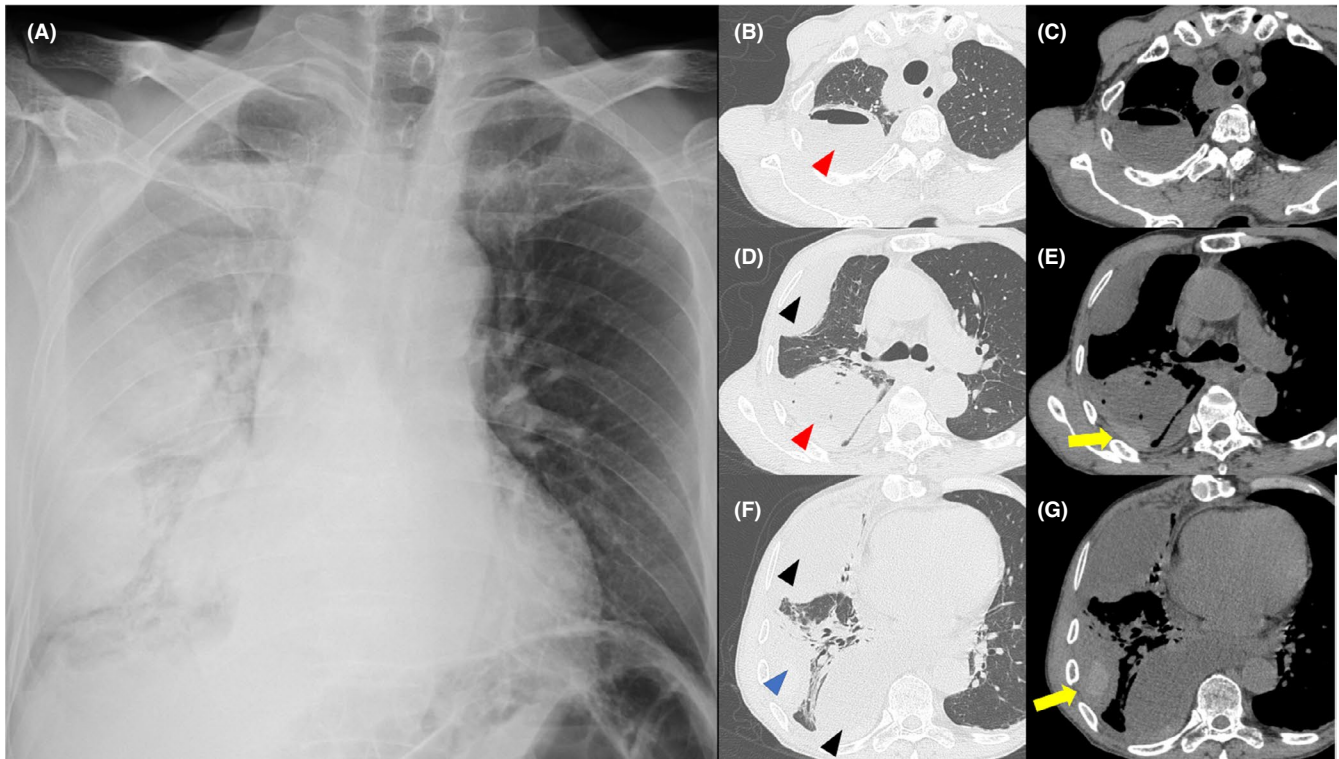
Chest imaging findings on admission. (A) Chest radiograph showing a large amount of right pleural effusion. (B–G) Chest computed tomography showing a large abscess in the lung with an air–fluid level in the right upper lobe (red arrowheads), a lung abscess in the right lower lobe (blue arrowhead), and large encapsulated pleural effusions (black arrowheads). The yellow arrows point to a high-attenuation area in the lung abscess, suggesting internal bleeding. Images B, D, and F show the lung window, and images C, E, and G show the plain mediastinal window
